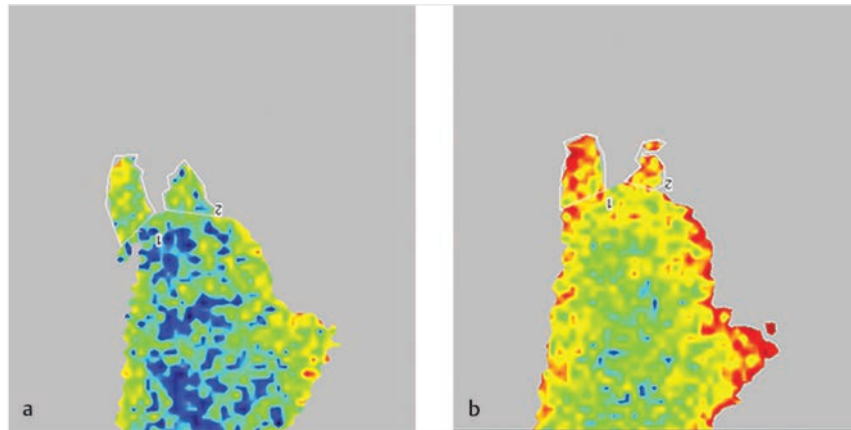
(a, b) Preoperative versus postoperative laser Doppler analysis demonstrating improved perfusion. (Adapted from Neumeister MW. Botulinum toxin type A in the treatment of Raynaud's phenomenon. *J Hand Surg Am* 2010;35(12):2085–2092.)
